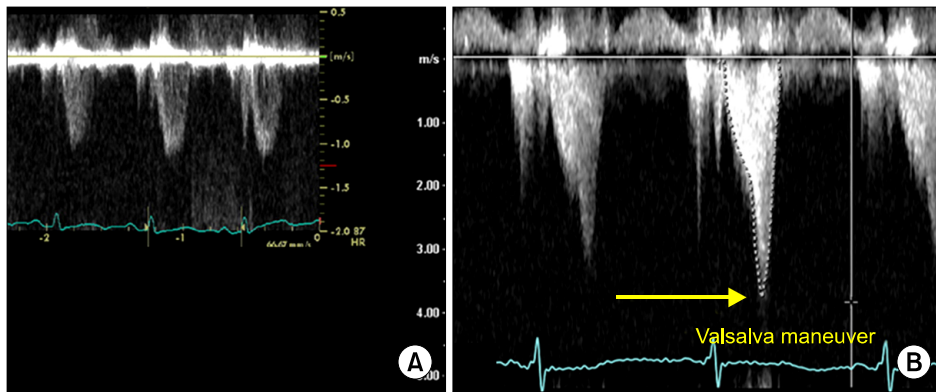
The change in the Doppler contour at the left ventricular outflow tract (LVOT). (A) The seemingly normal contour of the LVOT pulsed-wave Doppler image with normal velocity (1.2 m/sec) before coronary artery bypass grafting. (B) Echo performed when the patient suffered from anemia (hemoglobin, 8.3 g/dL). Dagger-shaped continuous-wave Doppler contour across the LVOT during the strain phase of the Valsalva maneuver. The peak velocity of the flow was more than 4 m/sec, and the pressure gradient was estimated to be 65 mmHg, suggesting significant subaortic obstruction. The patient's aortic valve was normal, and there was no evidence of a fixed obstruction at the aortic level, such as aortic stenosis or subaortic web.
